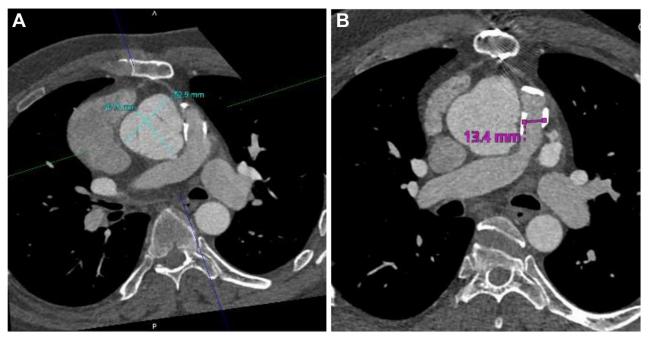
Cardiac computed tomography, multiplanar reconstruction, axial displays, demonstrates the aortic root dilation (A) and calcification with stenosis of the pulmonary homograft (B).
